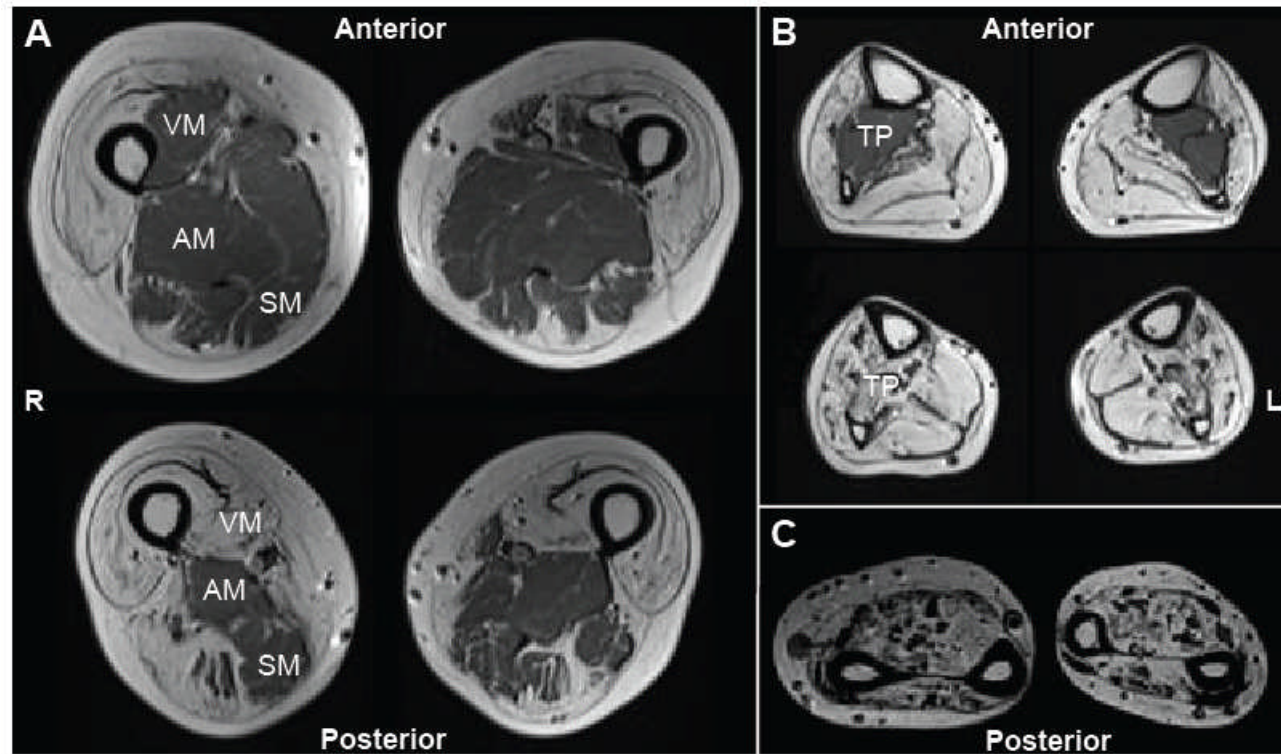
Axial T1 weighted MRI of thighs, calves and forearms of Patient 4.1. Proximal (top) and distal (bottom) thigh (A): severe fat infiltration and atrophy is seen in most muscles including quadriceps, gracilis and biceps femoris, with sparing of adductor magnus (AM) and semimembranosus (SM). A proximal-distal gradient is noted in muscles which are incompletely affected such as vastus medialis (VM). Proximal (top) and distal (bottom) calf (B): severe fatty atrophy of all muscles except tibialis posterior (TP) proximally. Mid-forearm (C): severe fatty atrophy of all muscles. R = right; L = left.
